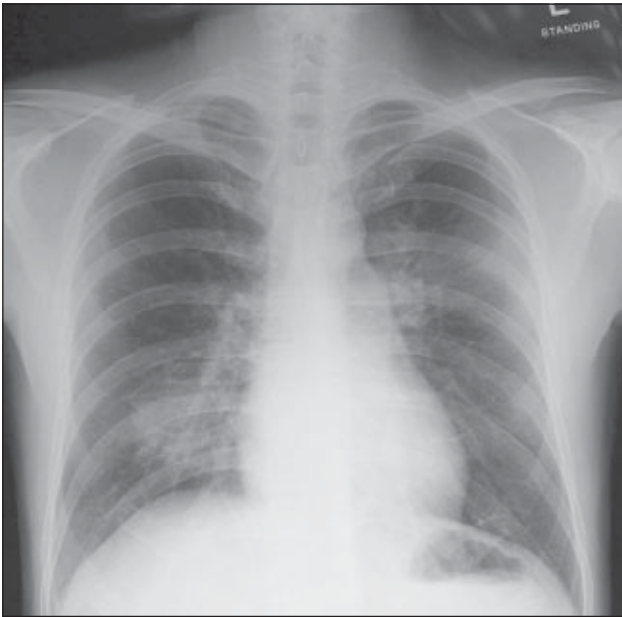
Chest X-ray performed on day 6 showed mild right lower lobe infiltrates
